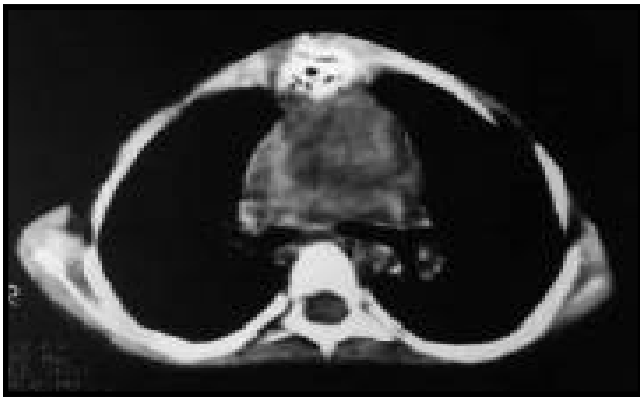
Magnetic resonance imaging (cross section of the chest) showing air-fluid at the site of the lesion around the sternal bone.
